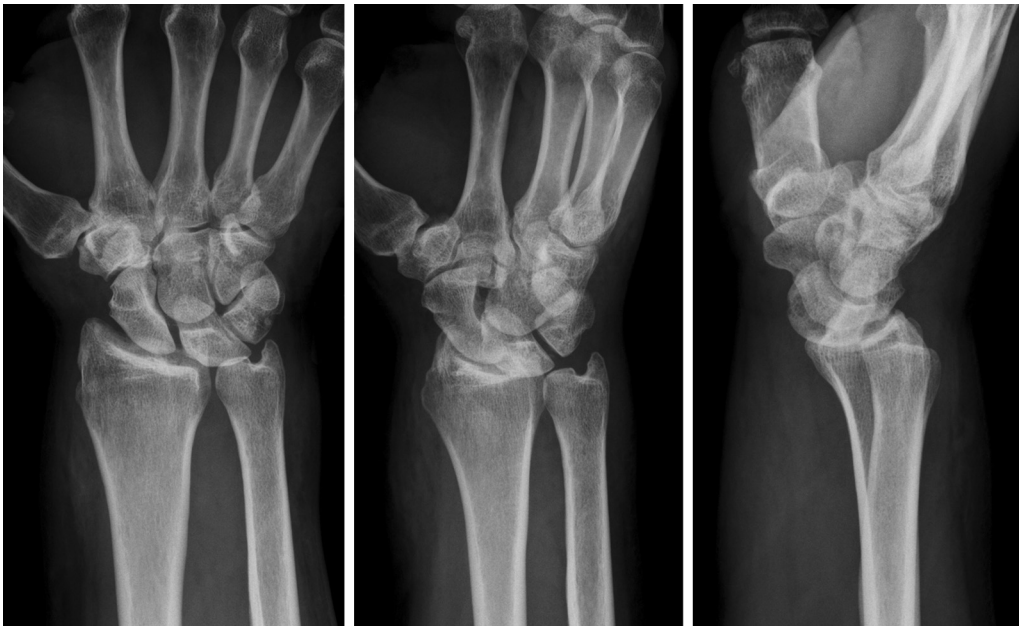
Radiographs of the initial injury (PA, oblique, and lateral views), demonstrating ulnar carpal translocation and volar radiocarpal subluxation. The capitulunate relationship is grossly maintained with no obvious intercarpal disruption. PA, posteroanterior.
